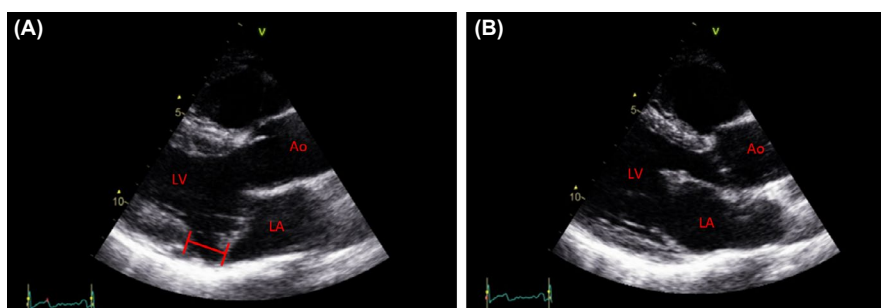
Parasternal long-axis view on transthoracic echocardiography showing mitral annular disjunction in ventricular systole (A) which is not present in diastole (B)
